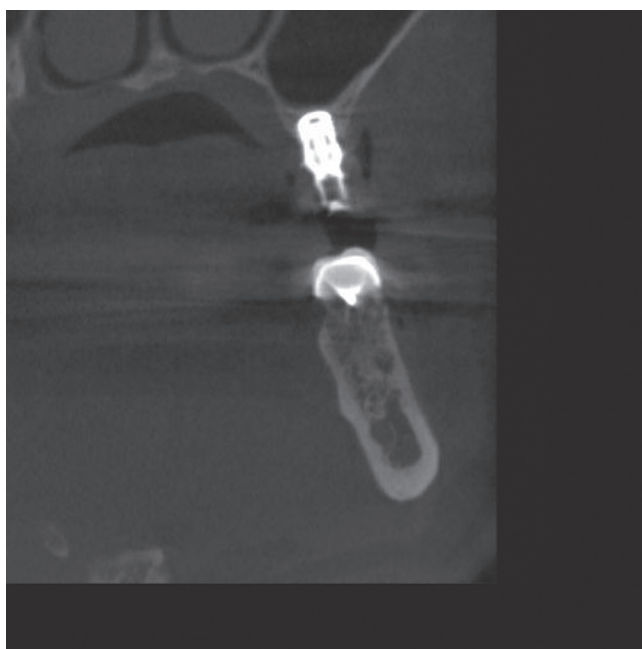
CBCT scan made 2 months after loading the implant with the temporary crown.
